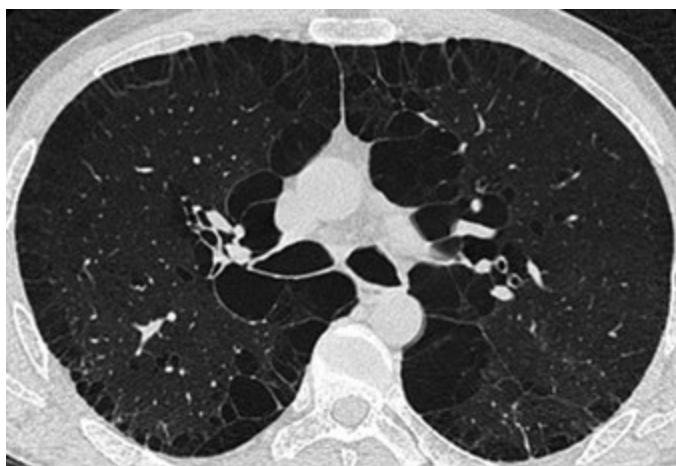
Well-demarcated peripheral emphysema on thoracic CT scan.
